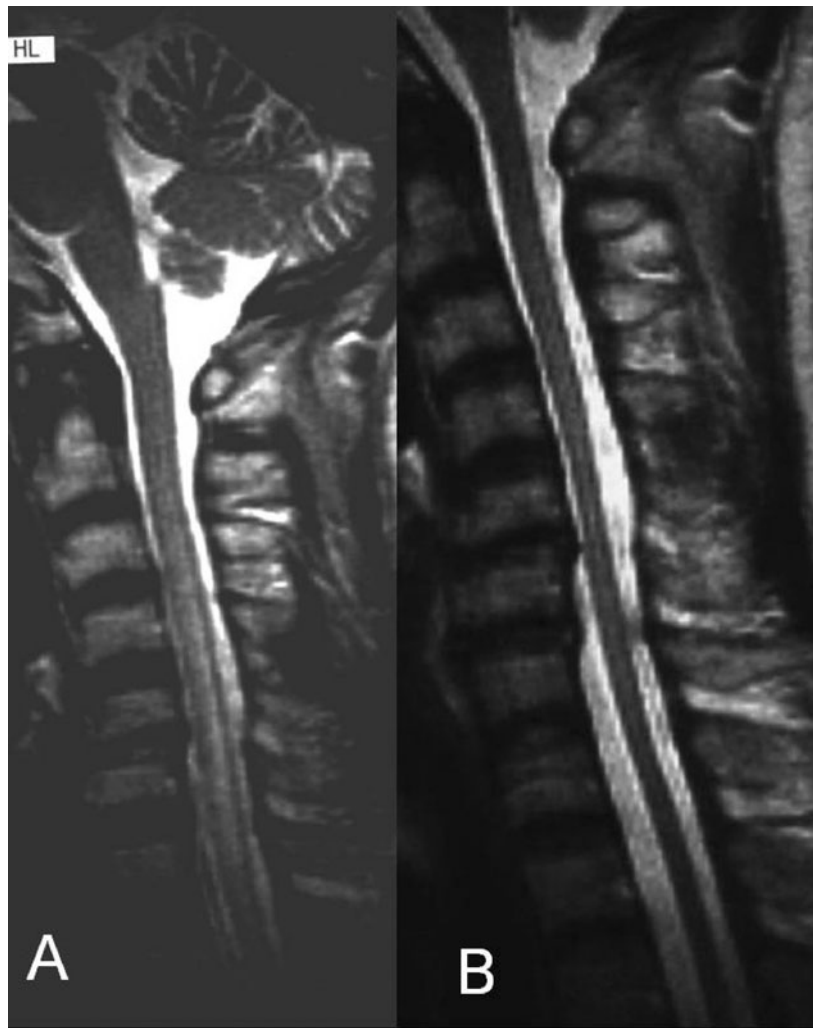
MRI from patient 2. Sagittal T1WI before (A) and after (B) treatment. Spinal cord swelling with high intensity signals on T2WI was reduced followed by spinal cord atrophy.
